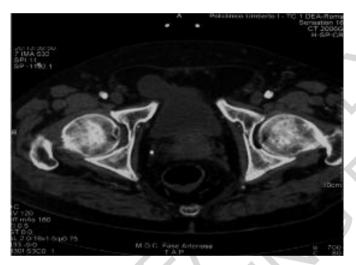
CT scan of the pelvis in axial projection, with arterial-phase contrast enhancement.
